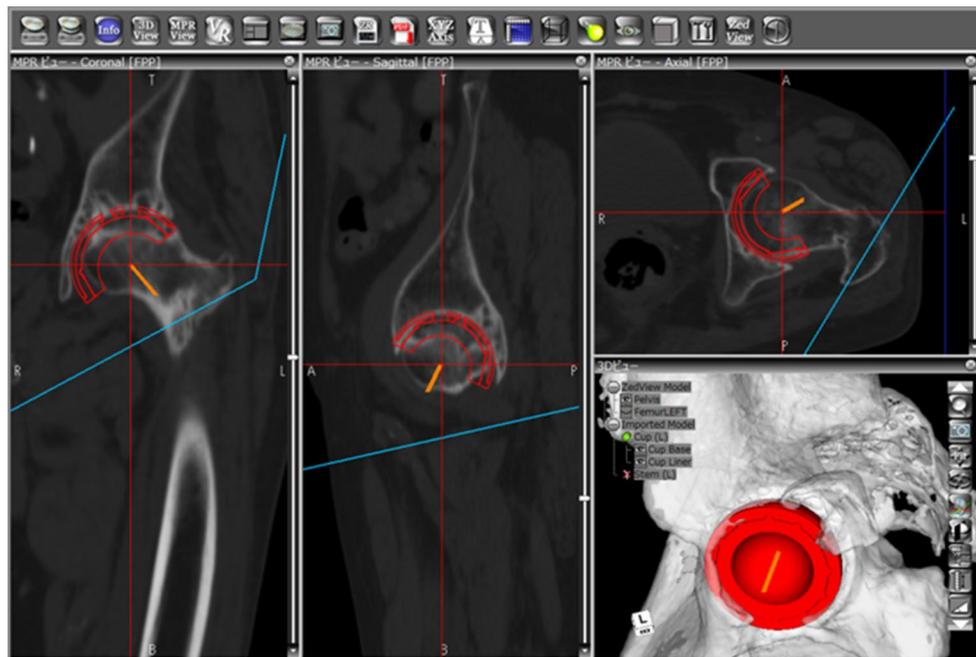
Preoperative planning for the acetabular component in a CT-based surgical preoperative planning system. Acetabular inclination and anteversion angle were planned according to APP. The cup size was chosen so as to fill the anterior and posterior acetabular walls
